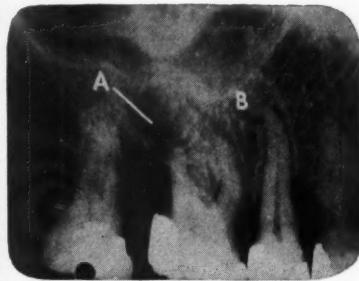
A, Marginal infective atrophy in periapical area of periodontal origin. B, Normal bone.
